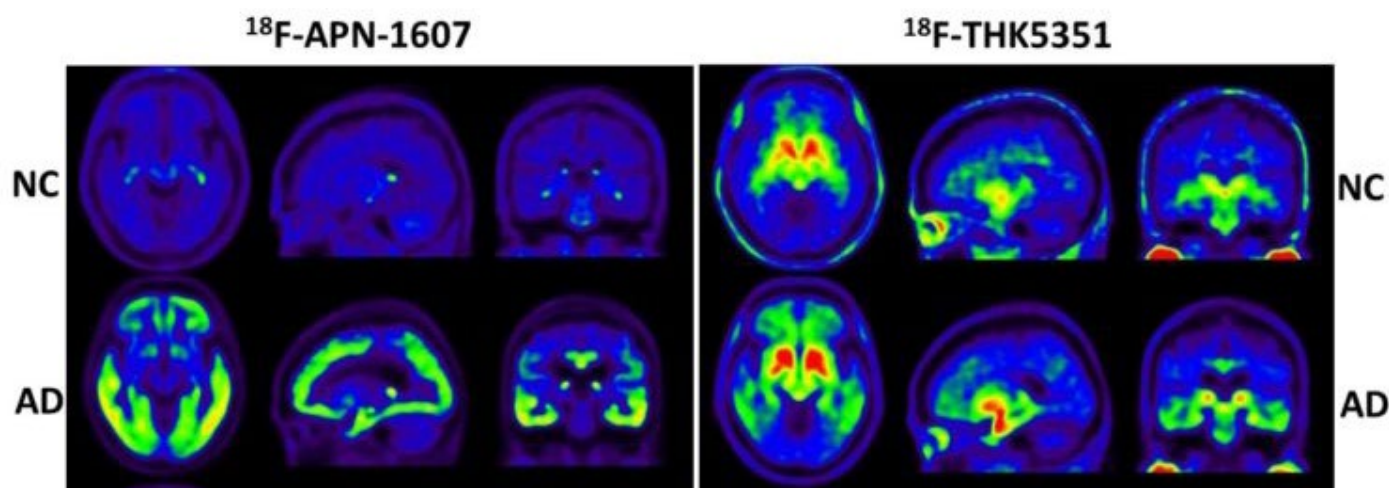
The mean SUVR images of NC (upper row) and AD (lower row) for both ^{18}F -APN1607 (left) and ^{18}F -THK5351 (right) imaging.
